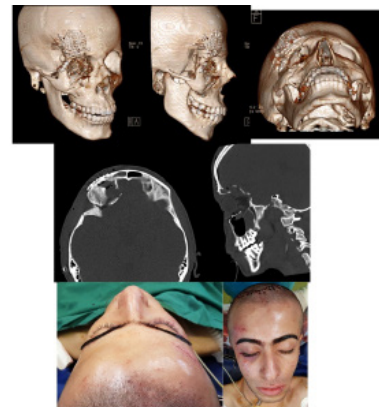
Final photos at the end of surgery and post-operative CT scan.
